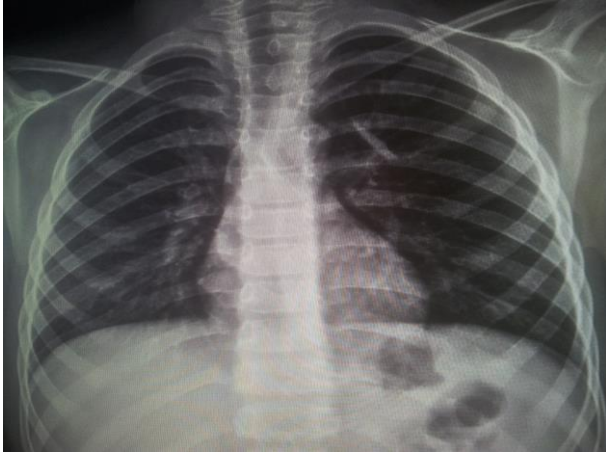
Posteroanterior radiograph showing the radiopaque FB in the left upper hemithorax
